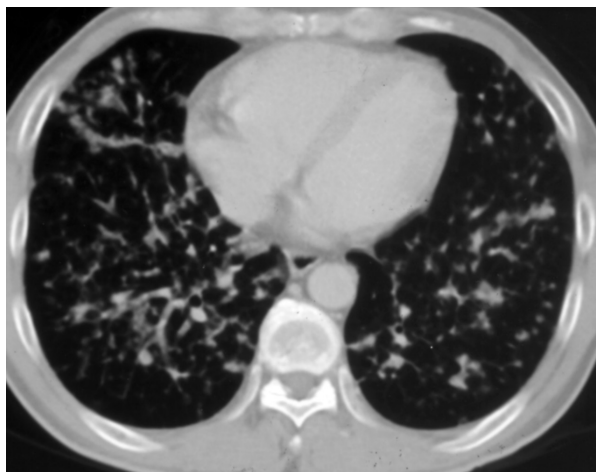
Chest CT with a lung window view, shows multiple nodules and thickening of the interlobular septa of both lungs.
